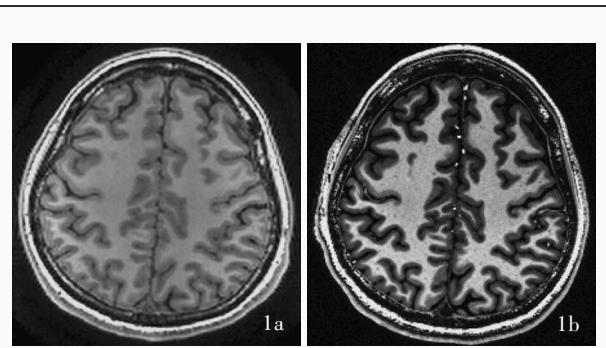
横断面T₁WI灰白质对比可见7T图像较3T图像灰白质对比度更高(灰质信号更低、白质信号更高),灰白质交界更清晰 1a 3T MRI 1b 7T MRI
